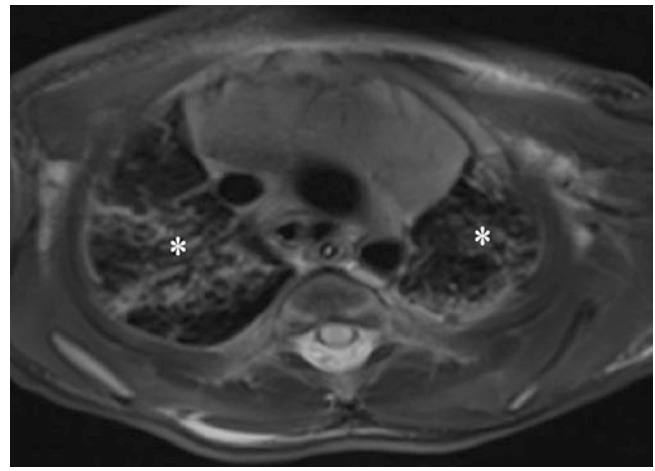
Respiratory syncytial virus infection in a 1-week-old girl who presented with respiratory distress. Axial non-enhanced T2-weighted fat-suppressed MR image shows bilateral peribronchial interstitial thickening (asterisks)
